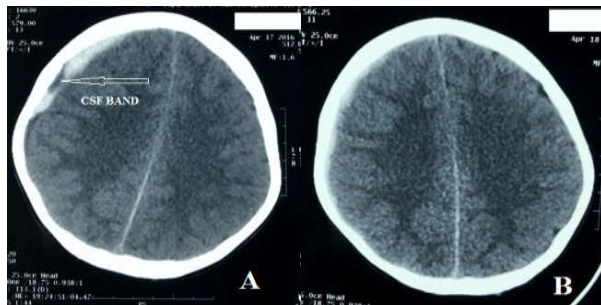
Case no 8. (A) Initial CT head having right side acute SDH and CSF band (arrow), (B) Repeat CT head of having rapid spontaneous resolution of SDH
